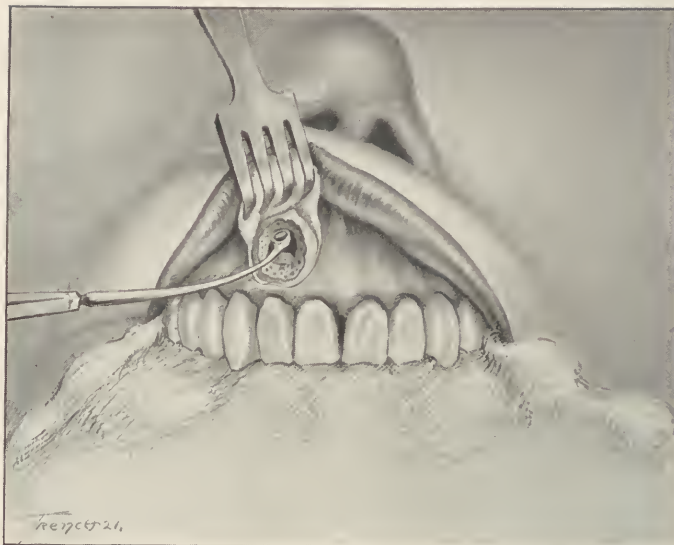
Root resection. Curettage of periapical area.
